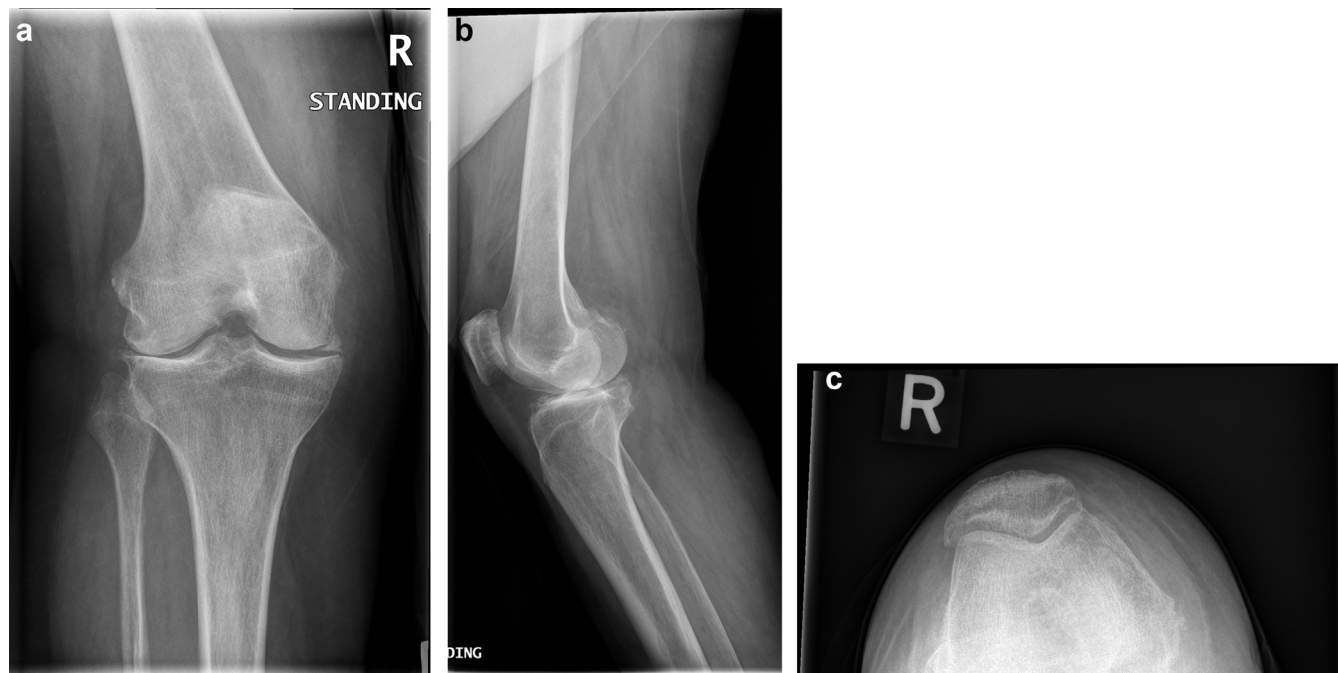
Preoperative (a) anteroposterior, (b) lateral, and (c) Merchant radiographs.
